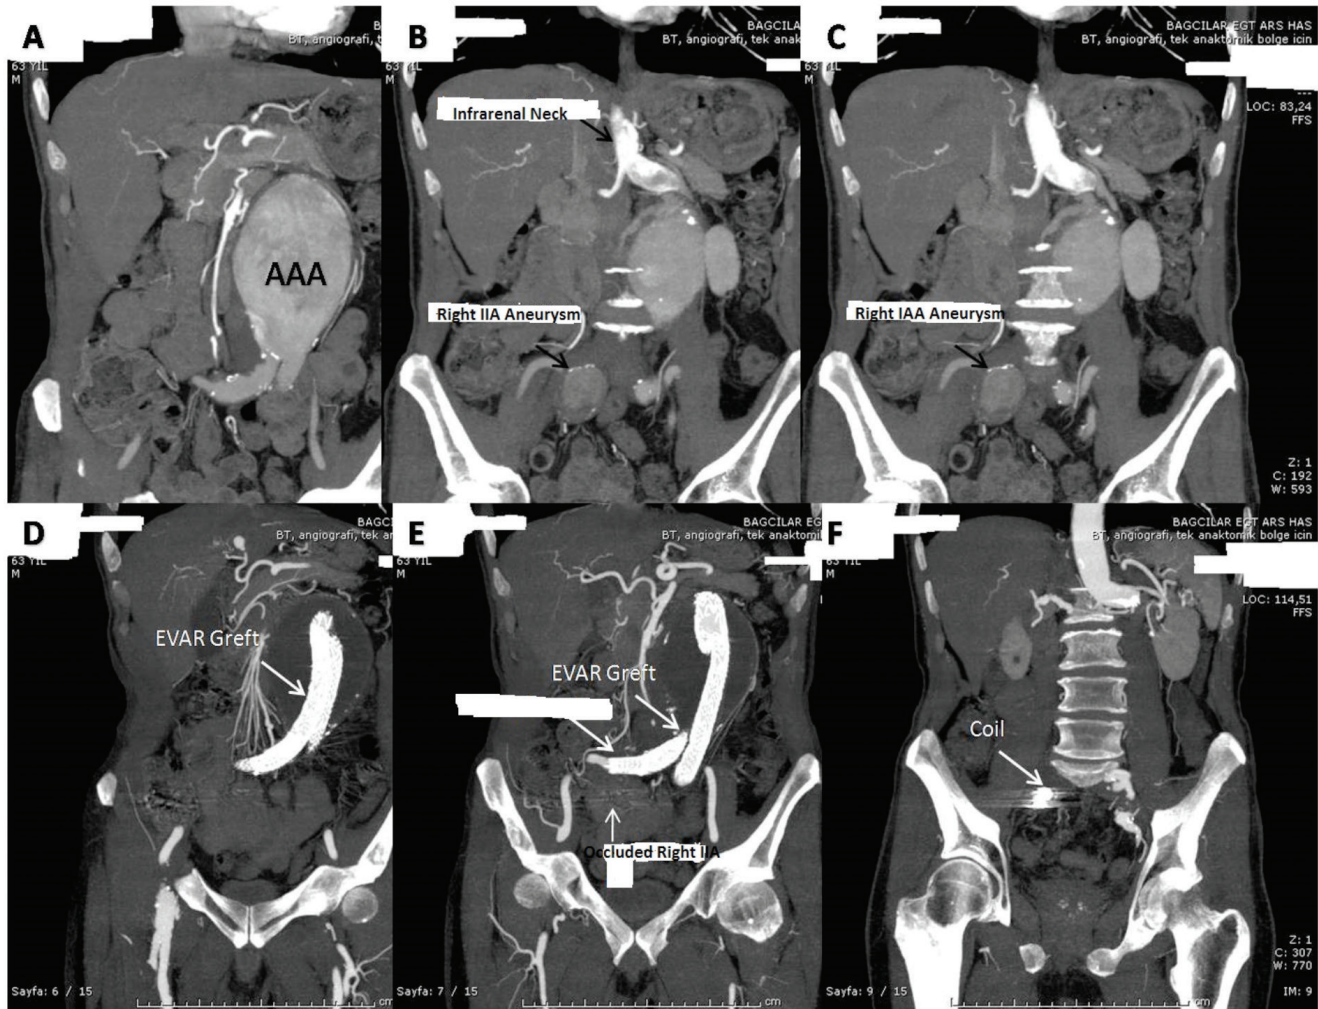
(A,B,C) CT angiography shows abdominal aortic and right internal iliac artery aneurysms, (D) Two months after the procedure, the EVAR graft was viewed by CT angiography, with no type of endoleak, (E,F) CT angiography shows the completely occluded right internal iliac artery and coil.
